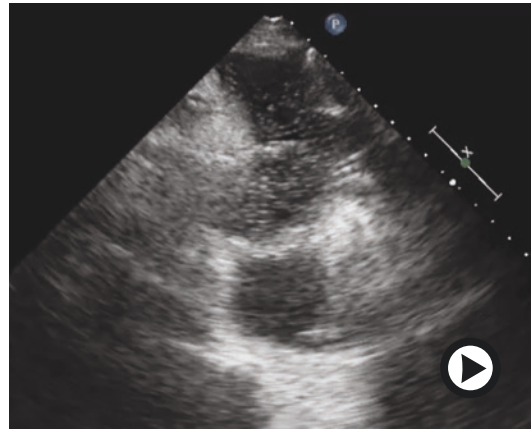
Short-axis injecting agitated saline through the catheter under direct ultrasound visualization, observing for formed microbubbles in the pericardial sac. (<https://doi.org/10.1007/000-2rq>)
